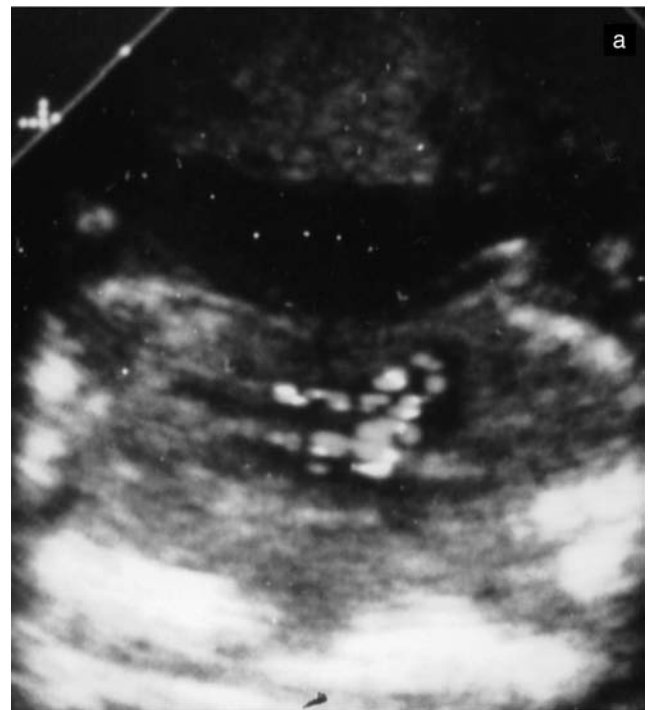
Conjoined twins mimicking a singleton pregnancy. Color-coded Doppler sonography. (a) A common fetal heart. (b) Two independent fetal hearts.
